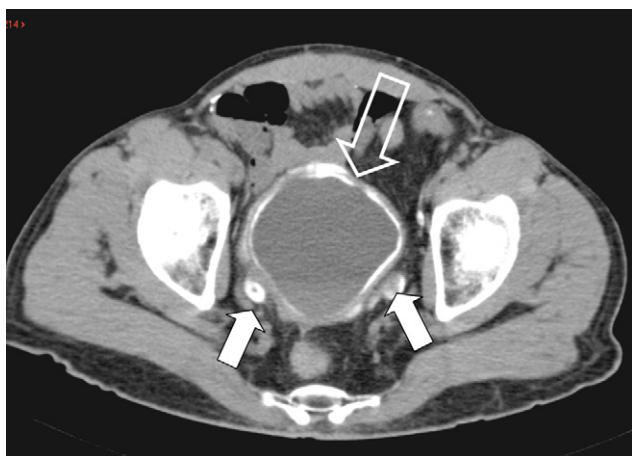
Bilharziasis. Axial view CT scan without injection of contrast medium: calcifications of the entire bladder urothelium (arrow outline) and of the distal portion of two ureters (solid arrows).
